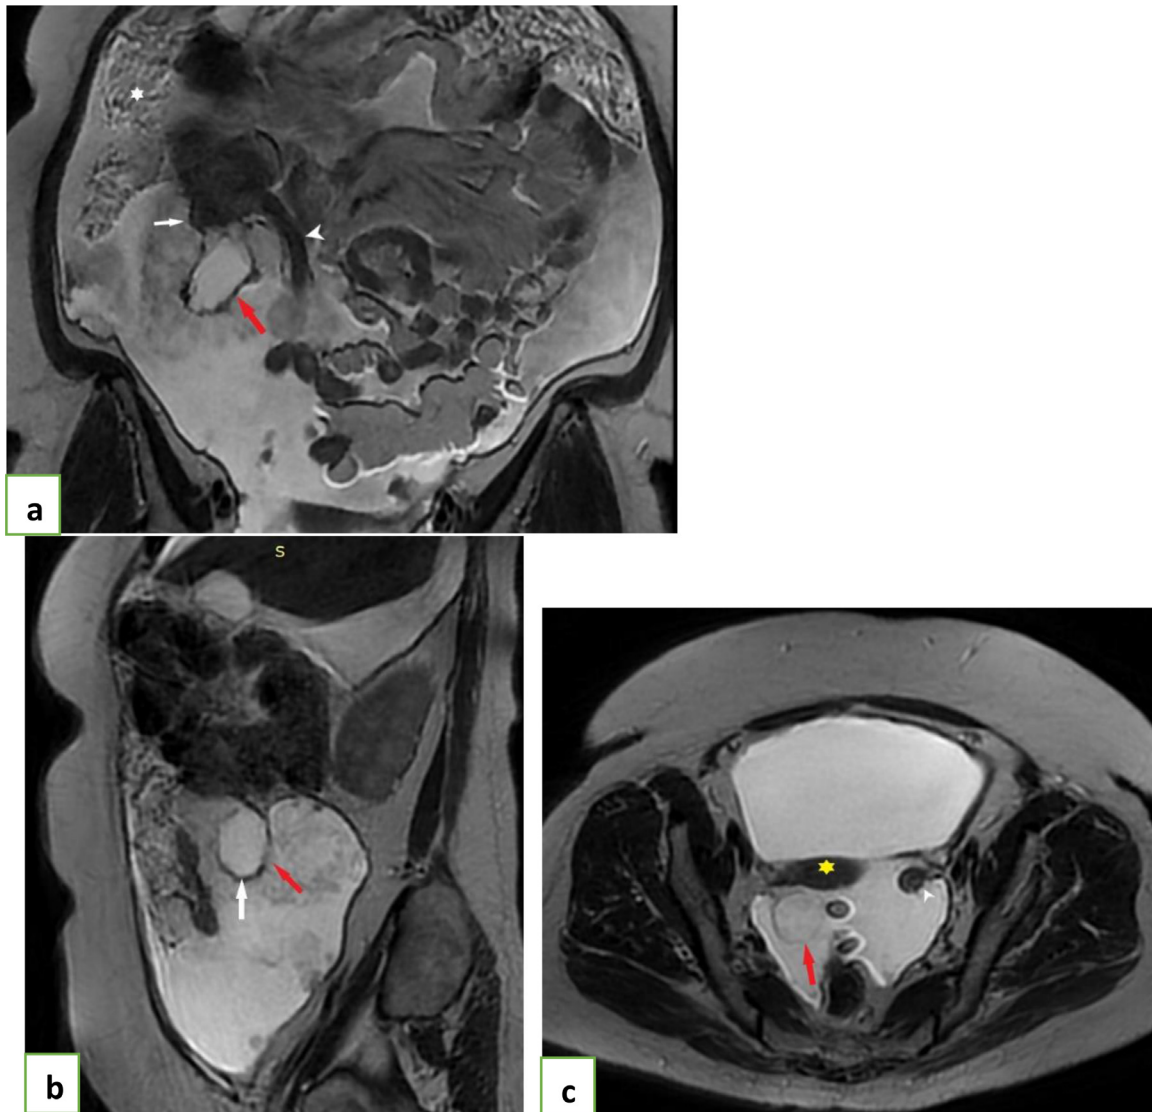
Abdominal MRI, T2 sequence, in the 3 planes; coronal (A), sagittal (B) and axial images (C) showing: A: A cystic mass (red arrow) attached to the caecum (white arrow), below the last ileal loop (head arrow). B: A discontinued wall (red arrow). C: A pelvic cystic mass (red arrow) with no ovarian abnormality (head arrow). (Color version of figure is available online.)
